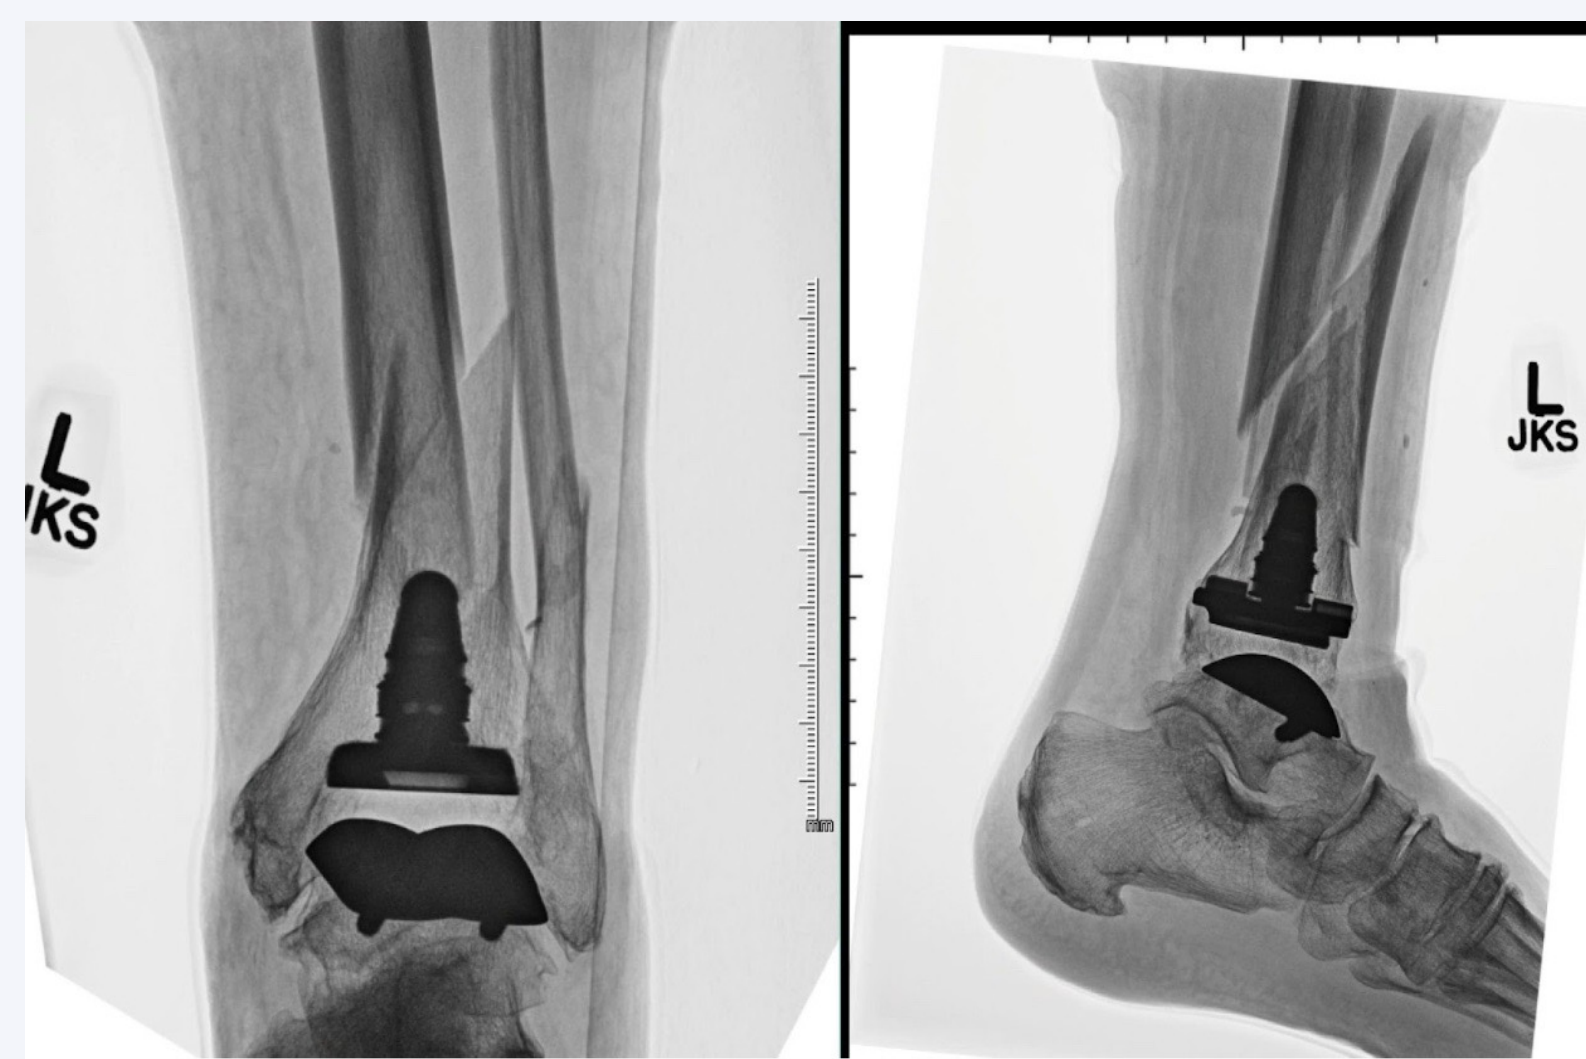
Patient 1 Anteroposterior (left) and lateral (right) radiographs of a 76-year-old female with a previous total ankle arthroplasty who presented after a fall and sustained a traumatic periprosthetic ankle fracture. This represents a Hill-Brown type AF/B1 fracture as shown in Table 1.
